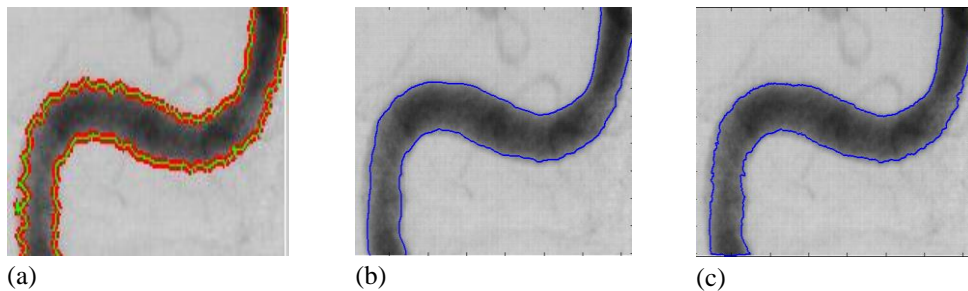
Experiments on the second type of blood vessel X-ray images. The final results using the C-V, SGLACM, and proposed methods are shown in the first, second, and third columns, respectively. The parameter of $\alpha=0.06$ and $\sigma = 3$.
